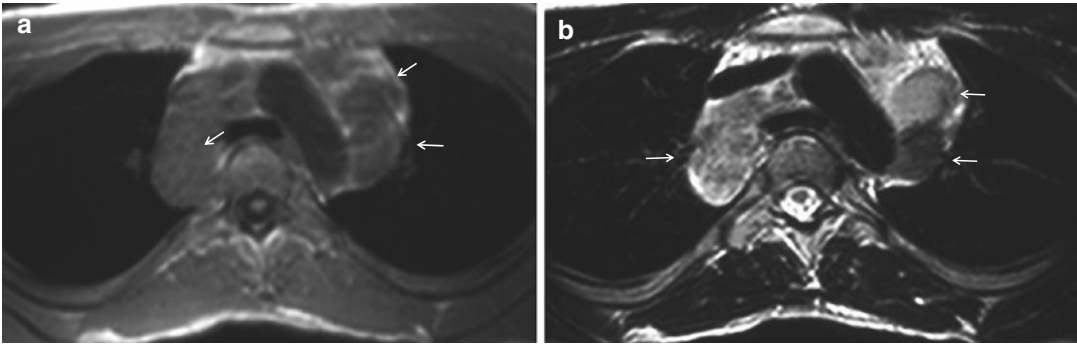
Anaplastic diffuse large B-cell lymphoma. T1-weighted (a) and T2-weighted (b) images show multiple enlarged lymph nodes (arrows) in the anterior mediastinal, paratracheal, and posterior mediastinal regions
